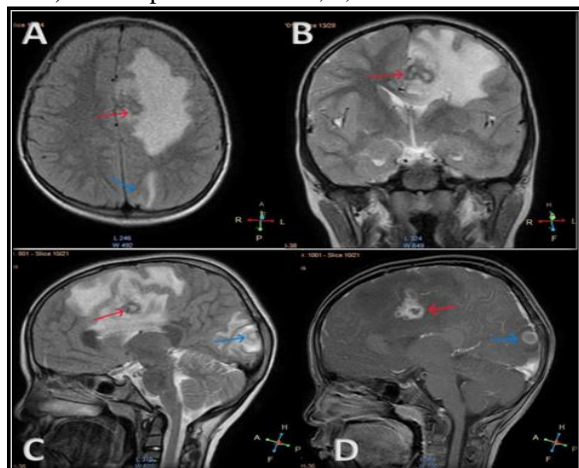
(case 7) FLAIR (A), T2 (B, C) AND CISS (Constructive interference in steady state) sequence (D) showing conglomerated lesion (red arrow) in colloid-vesicular stage cyst with extensive perilesional oedema with midline shift. A solitary cyst in colloid-vesicular stage is also seen in left occipital lobe (blue arrow).
